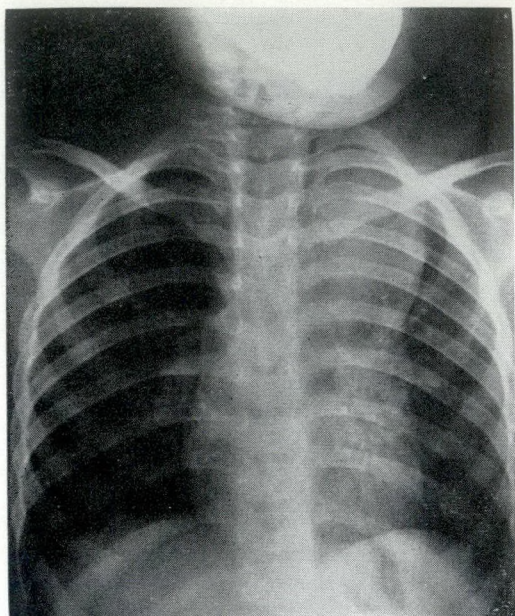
Miss M.N. Radiograph of chest showing large shadow in left upper zone.
